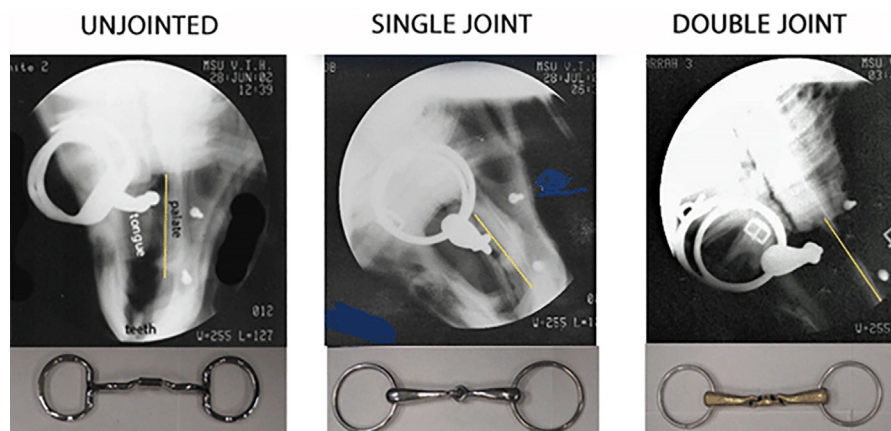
Lateral radiographs of unjointed (*left*), single-jointed (*center*), and double-jointed (*right*) snaffle bits. Dorsal to the right. Yellow line shows position of the hard palate. Note how far the bits hang down on the tongue in each image, which can be assessed by the distance from the most rostral part of the bit to the rostral edge of the first cheek tooth. Note also the proximity of the 3 bits to the line representing the hard palate.
